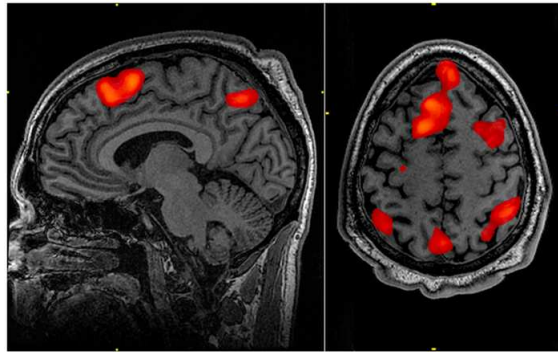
MRI scan during memory tasks
